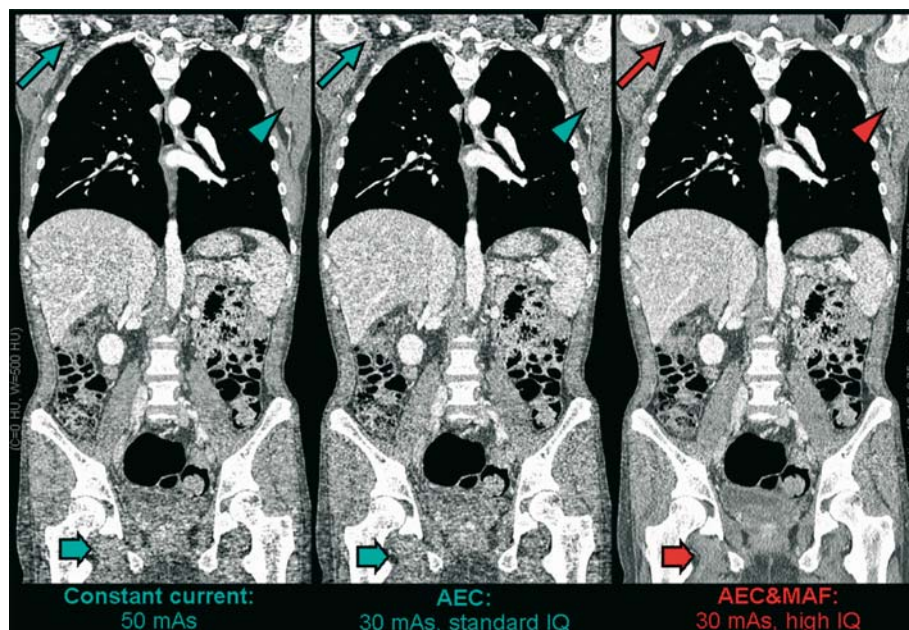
Automatic exposure control in CT. In standard scanning with constant tube current (*left*) image quality varies with anatomical level. Modulation of the tube current with projection angle and z-position allows to reduce mAs significantly without a loss in image quality (*middle*). Adaptive filtering which does not impair resolution leads to improved image quality at reduced mAs (*right*)
